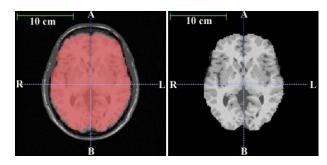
Skull-stripping result shown on an axial slice of one T1-weighted Brainweb image. From left to right: Original image with mask overlay; Brain tissues after applying the skull-stripping mask^[20].
